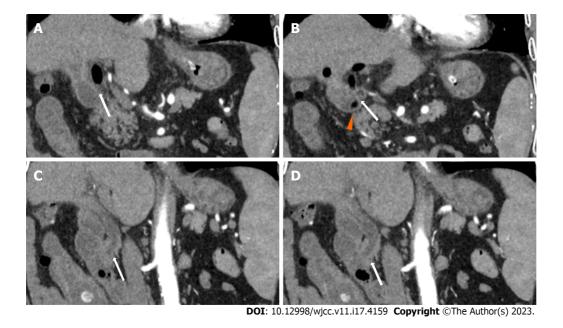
Abdominal contrast enhanced computed tomography (coronal view) showing cholecystoduodenal fistula. A-D: Abdominal contrast computed tomography showed pneumatosis in the gallbladder (orange arrows), and the gallbladder communicated with the duodenal bulb (white arrows), indicating a cholecystoduodenal fistula.
